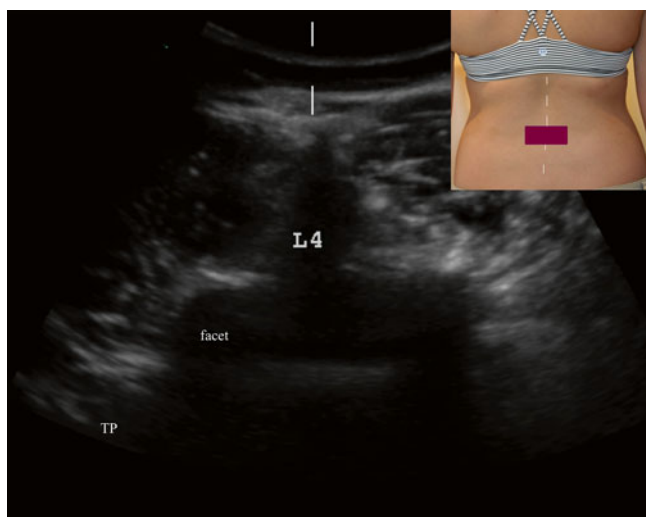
Ultrasound image of horizontal approach to the lumbar plexus (Image courtesy of Andrea Trescot, MD)
